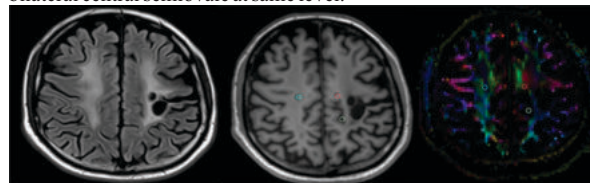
a & b. FLAIR Axial image shows hyperintense foci in deep white matter including bilateral centrum semiovale, b. T1W hypointense foci in the frontal lobes, with small lacunar infarcts [at other level - not seen in these images] and cerebral atrophy. c. DTI axial image with ROIs on the anterior and posterior side parts of frontal lobe.
